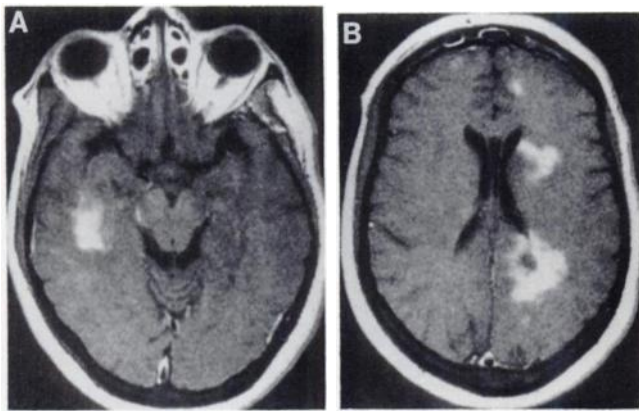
First MR (1.0T): First Gd-DTPA enhanced T1-weighted MR (TR 600/TE 15) shows intense enhancement in the right temporal lobe (A) and different regions of the left hemisphere (B).
